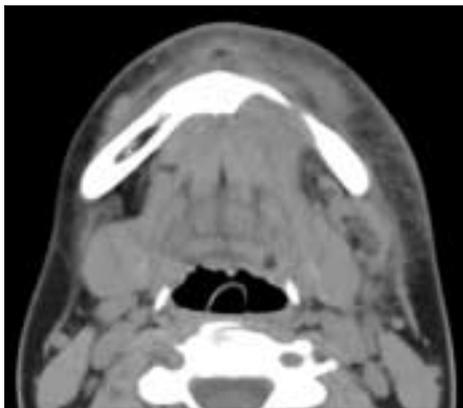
Axial computed tomography scan showing an erosive lesion at the mandibular body.
